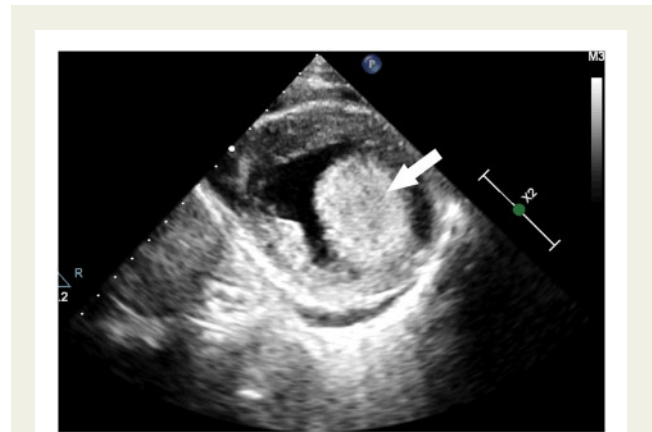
From a parasternal short-axis view, the transthoracic echocardiogram revealed a 76 mm × 42 mm × 62 mm cardiac mass located at the apex and middle segment of the left ventricular wall without a clear boundary with healthy myocardial tissue (white arrow).
